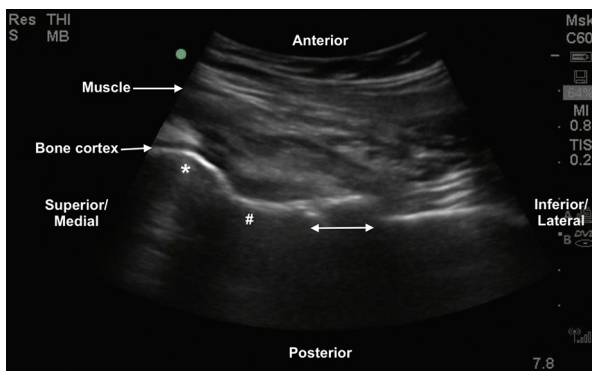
Point-of-care ultrasound of the right hip along the axis of the femoral neck. Superior/Medial has been labeled in the image to reflect that the directional indicator is oriented toward the umbilicus parallel to the axis of the femoral neck. The cortex of the femoral head (*) and neck (#) is normal, but there is an irregularity and abrupt break in the cortex of the femur (double headed arrow) concerning for a fracture.
